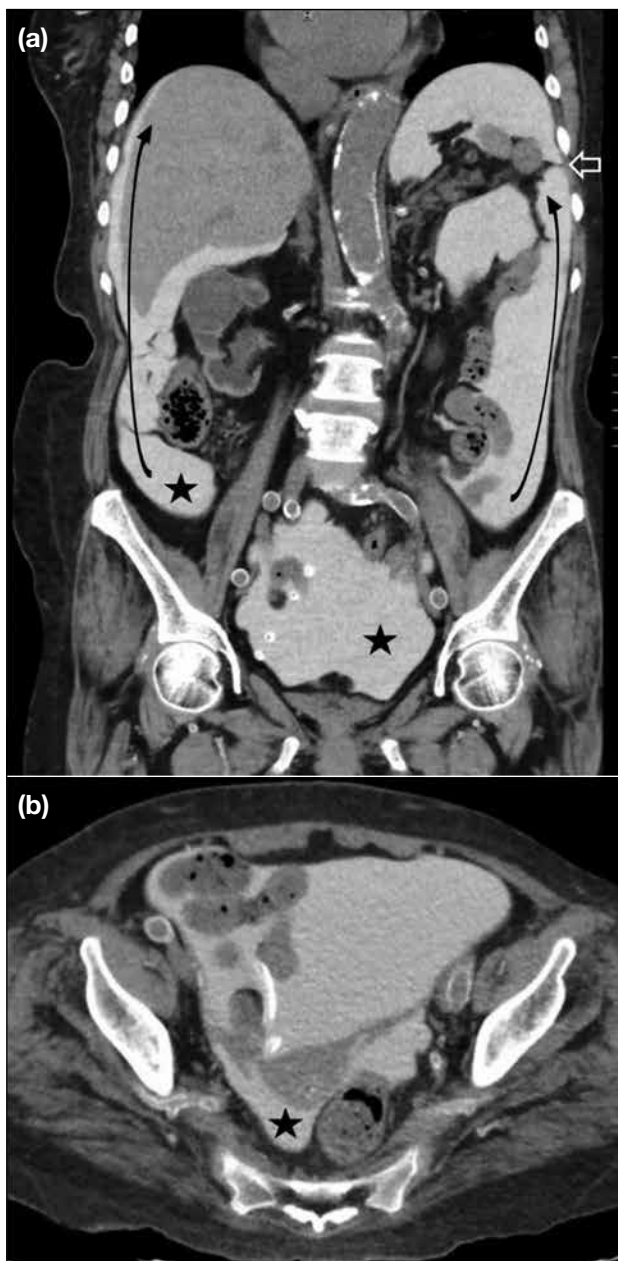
(a) Coronal and (b) axial images of computed tomography peritoneogram with intraperitoneal contrast to demonstrate peritoneal cavity anatomy. Peritoneal fluid initially collects at the pelvis, then travels cephalad due to pressure gradients produced by inspirations (curved arrows in [a]). Fluid passage on the left side is superiorly limited by the phrenicocolic ligament (open arrow in [a]). The rectouterine pouch, right lower quadrant, sigmoid colon, and right paracolic gutters (asterisks in [a] and [b]) are dependent regions in which there is stasis of peritoneal fluid.
